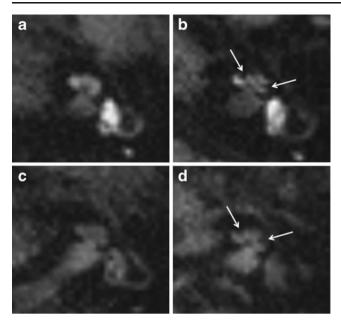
3D-FLAIR images of the left cochlea at the level of the modiolus of a 67-year-old woman (a), a 68-year-old man (b), a 63-year-old woman (c), and a 28-year-old man (d) with suspected Ménière's disease are presented. Images a and b were obtained 24 h after intratympanic gadolinium injection and images c and d were obtained 4 h after intratyenous gadolinium injection. On all images, the perilymph of the cochlea shows a high signal intensity. On images b and d, significant endolymphatic hydrops in the cochlea can be recognized as areas of low intensity (*arrows* on b and d) and the area of the endolymphatic space exceeds the area of the scala vestibule (endolymphatic hydrops grade 2). In contrast, on images a and c, there are no endolymphatic hydrops in the cochlea and the recognition of the endolymphatic space is difficult (endolymphatic hydrops grade 0)
